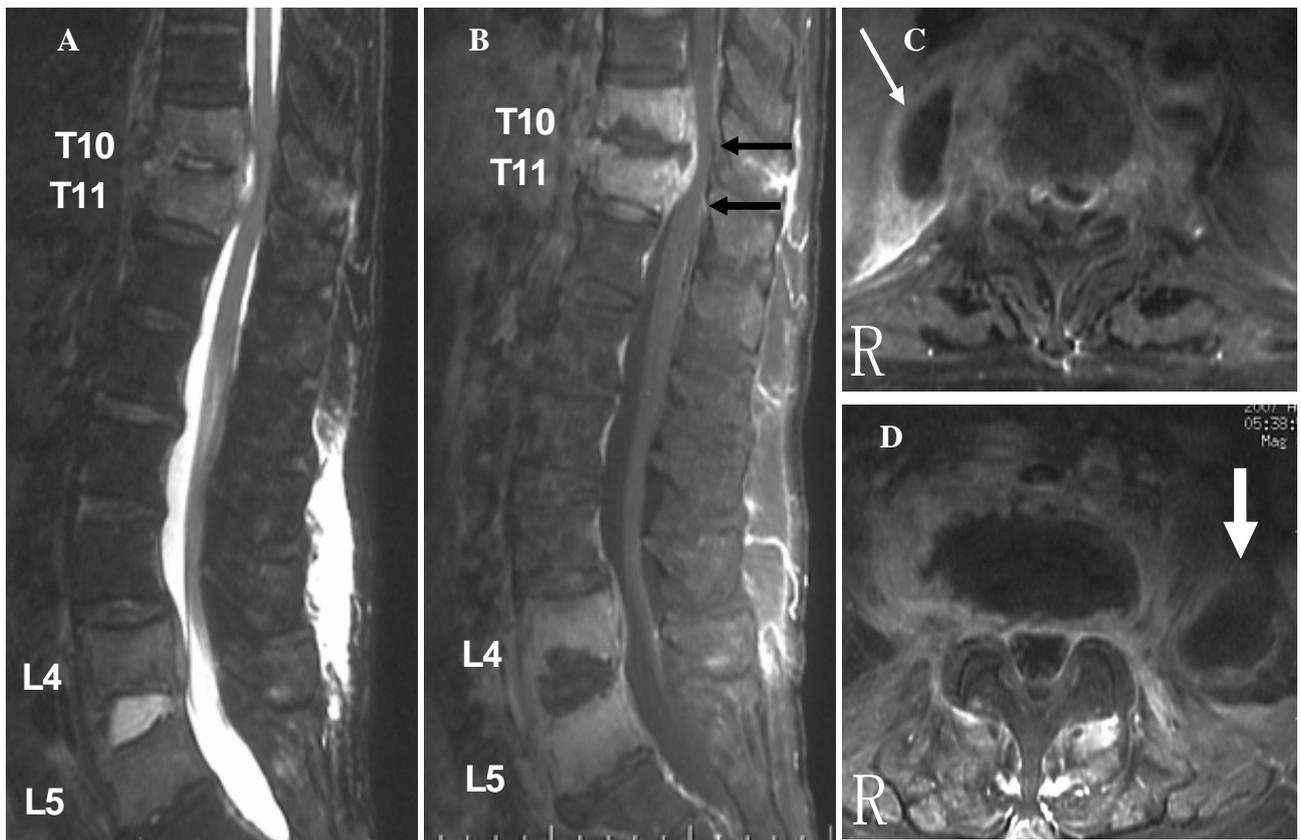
Preoperative magnetic resonance (MR) images of the thoraco-lumbar spine taken on the admission day. A: Sagittal fat suppression T2-weighted MR image showed that signal intensities of T10, 11, L4, and L5 vertebral bodies were increased compared with other vertebral bodies. B: Sagittal T1-weighted MR image with gadolinium revealed that vertebral bodies of T10, 11, L4 and L5 were well enhanced. The spinal cord is compressed from the ventral side by the enhanced mass lesion in the T10-11 level (arrows). C: Axial T1-weighted image at T10 level showing ring enhanced lesion, which is interpreted as an abscess, in the right paravertebral region (white arrow). D: Axial T1-weighted image at L4-5 level showing ring enhanced lesion, which is also interpreted as an abscess, in the left iliopsoas muscle (white arrow).
